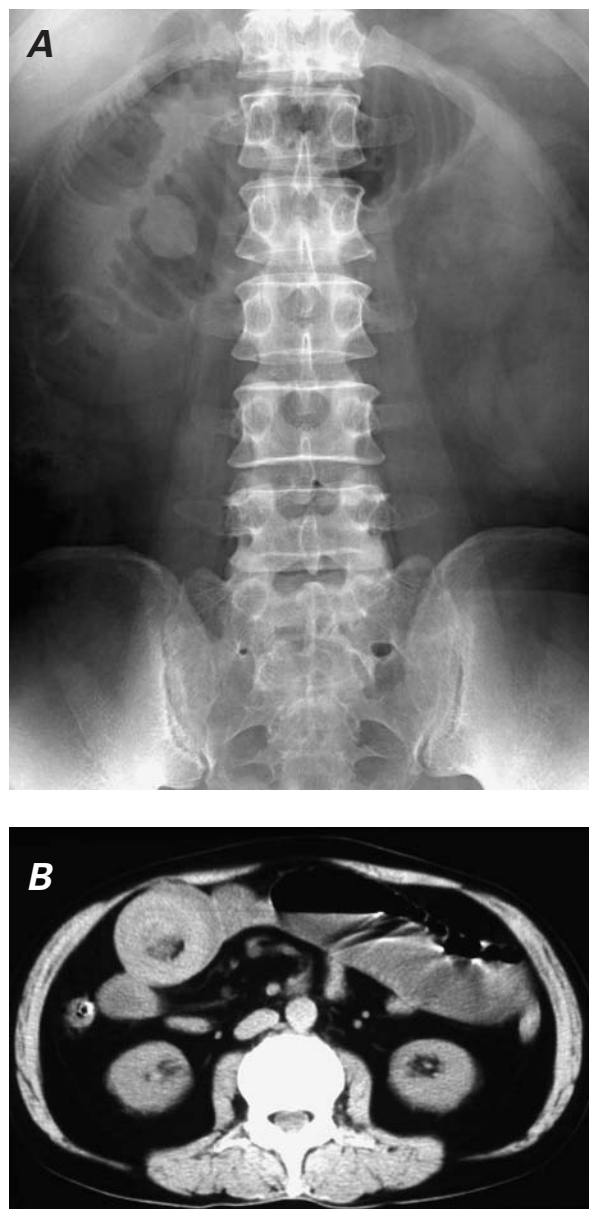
A) Abdominal radiograph of the patient in the upright position on admission to the hospital with frequent vomiting. B) Abdominal computed tomographic scan, used in the diagnosis of intussusception of the small bowel, shows a thick-walled loop of bowel with infolding bowel, indicated by a bull's-eye sign.
